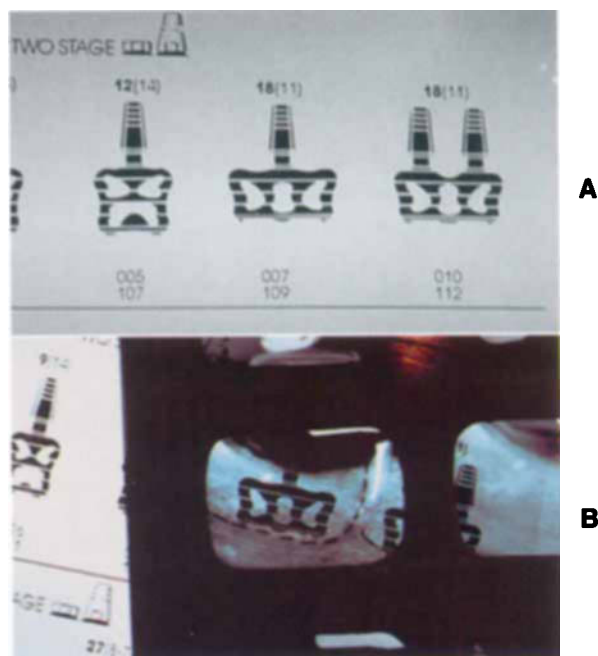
■ Implant overlay (A) placed over periapical radiograph indicates that base of implant is too close to canal (B).
